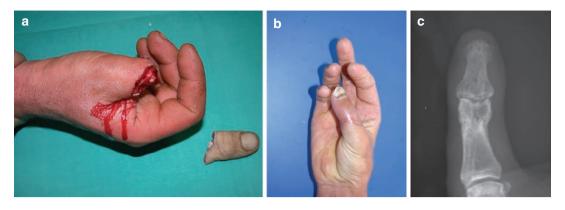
(a) Thumb amputations at P1 level by circular saw. (b and c) Clinical and radiographical result at 6 months
